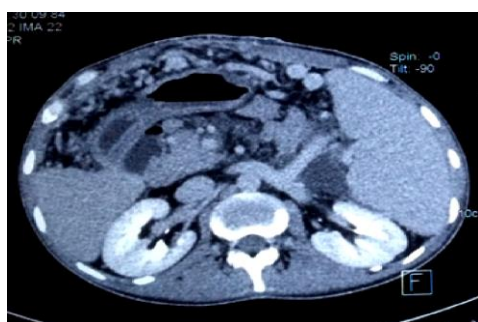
CT scan image showing the splenorenal shunt
